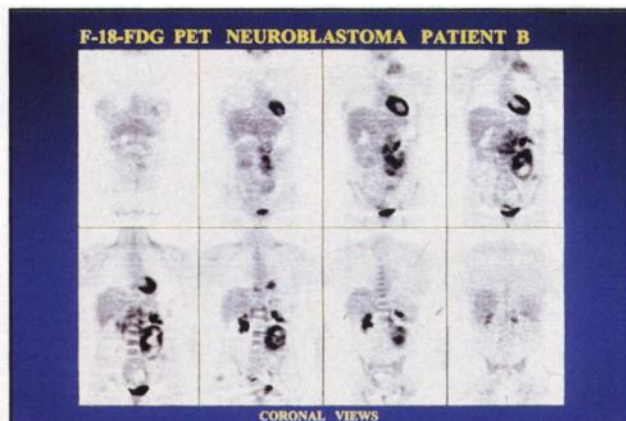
The lesion accumulates FDG.
